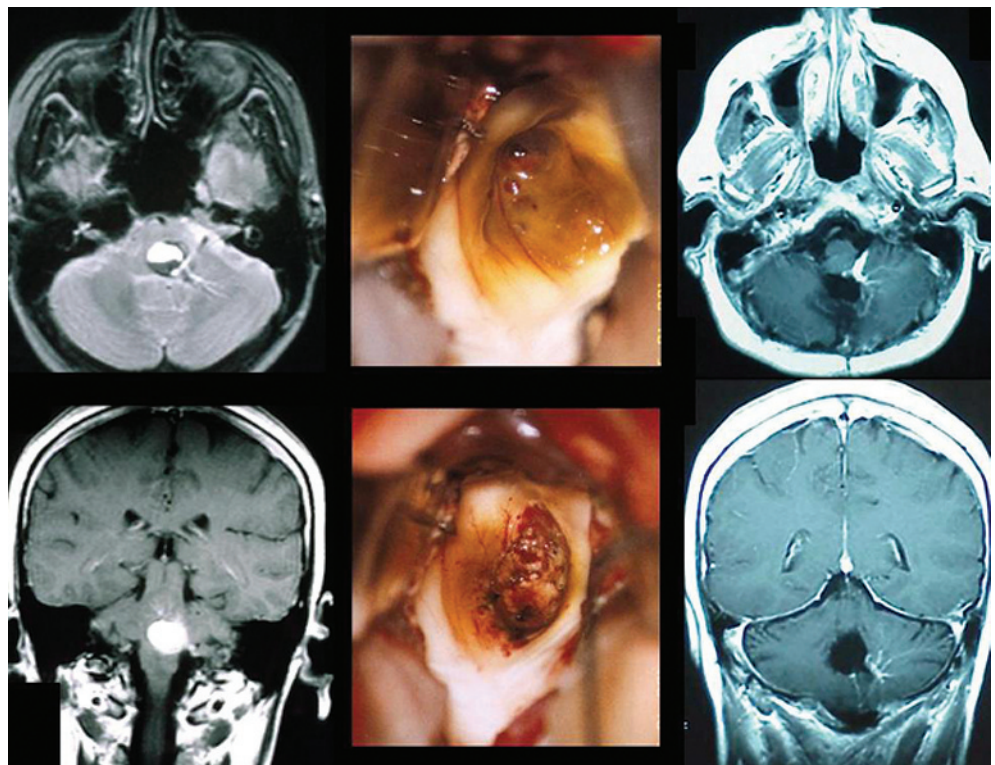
Left, preoperative MRI demonstrating IV ventricle cavernous malformation with associated developmental venous anomaly (DVA). Center, intraoperative photographs of surgical removal. Right, postoperative MRI documenting complete removal of cavernous malformation and sparing of the DVA.
